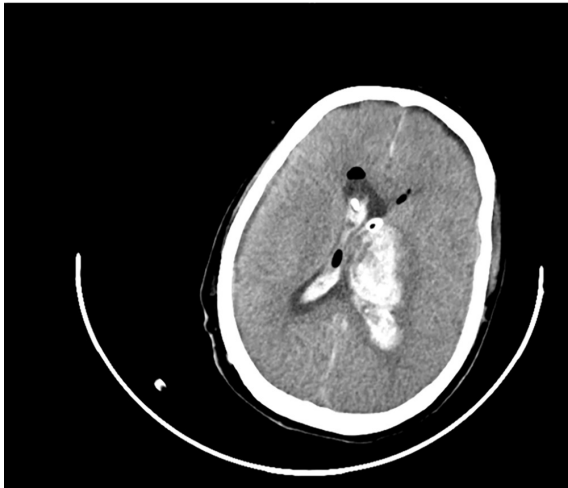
Brain CT scan demonstrates severe intracranial hemorrhage 2 days after tumor resection surgery.
